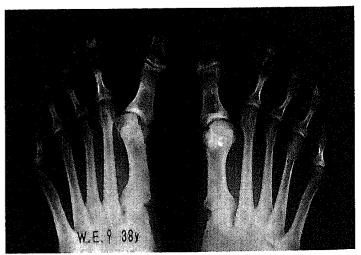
Patient 16. Radiographs were obtained 13 years after surgery. Hallux varus deformity was seen on both sides, with a 28° hallux varus deformity on the left side. The patient was dissatisfied, and additional surgery was planned.
